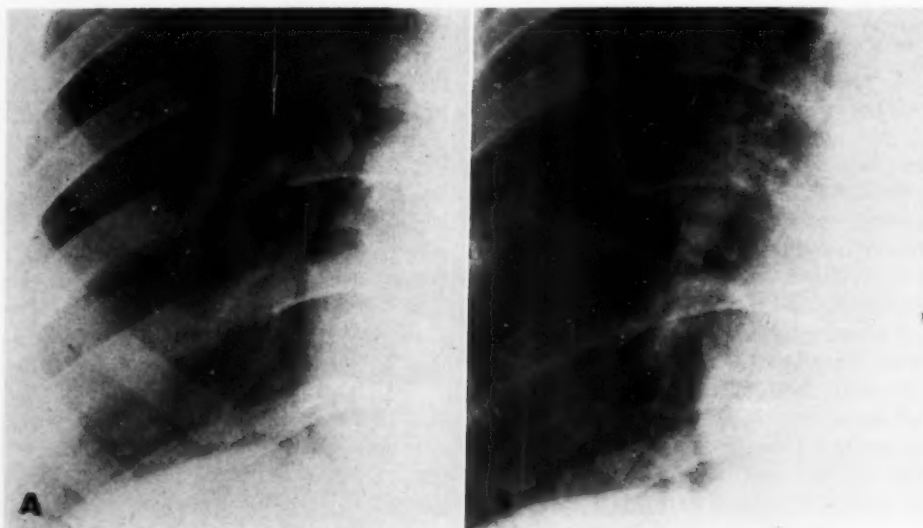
A. Chest roentgenogram obtained prior to identifiable thoracic disease. The right pulmonary artery is normal in appearance. B. Twenty-eight months later, the contours of the pulmonary artery area are noticeably changed. Although the width of the "artery" is not beyond an anticipated normal size, its shadow is larger than in A, and there is irregularity of its contours.
